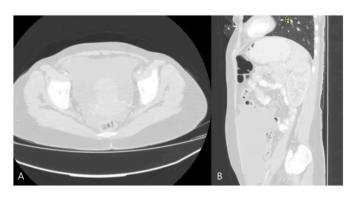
(A) Axial and (B) sagittal computed tomography (CT) images show an irregular cystic-appearing mass, measuring 25 \times 10 cm.
